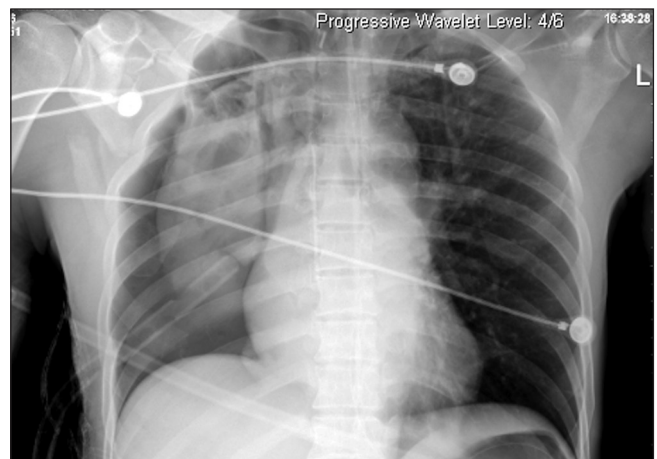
Chest X-ray demonstrated a new large pneumothorax and collapse of whole the right lung
